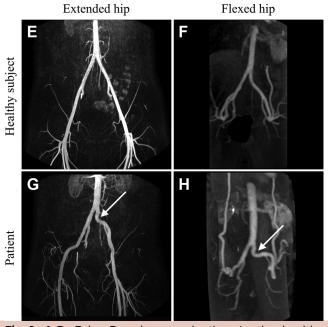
A-D, Echo Doppler examination. In the healthy subject, the iliac axis follows a normal course with extended and flexed hip (A, and B, *white arrows*). In a patient with FLIA owing to lengthening, the iliac external artery is lengthened in rest, and kinks with flexed hips (C, and D, *white arrows*). E-H, Contrast-enhanced magnetic resonance angiography (*CE-MRA*). In a healthy subject, the visualization of arteries with extended and flexed hips is rather straight (E and F). In contrast, excessive lengthening in a FLIA patient may already be present with extended hips (G. *white arrow*). Moreover, kinking with flexed hips may occur (H, *white arrow*).¹³
